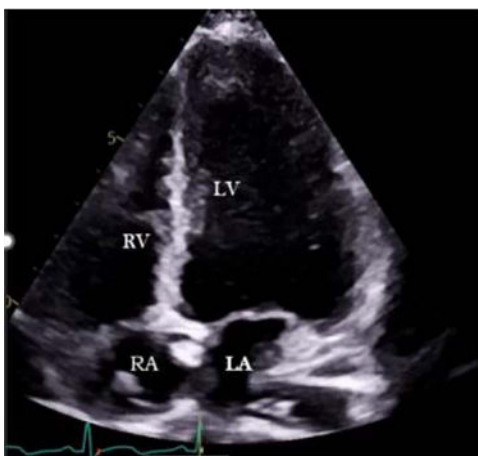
Ultrasound image of the apical four-chamber view of the focused cardiac ultrasound (FOCUS) examination. LA, left atrium; RV, right ventricle; RA, right atrium; LV, left ventricle (figure courtesy of Vrushali Ponde).
